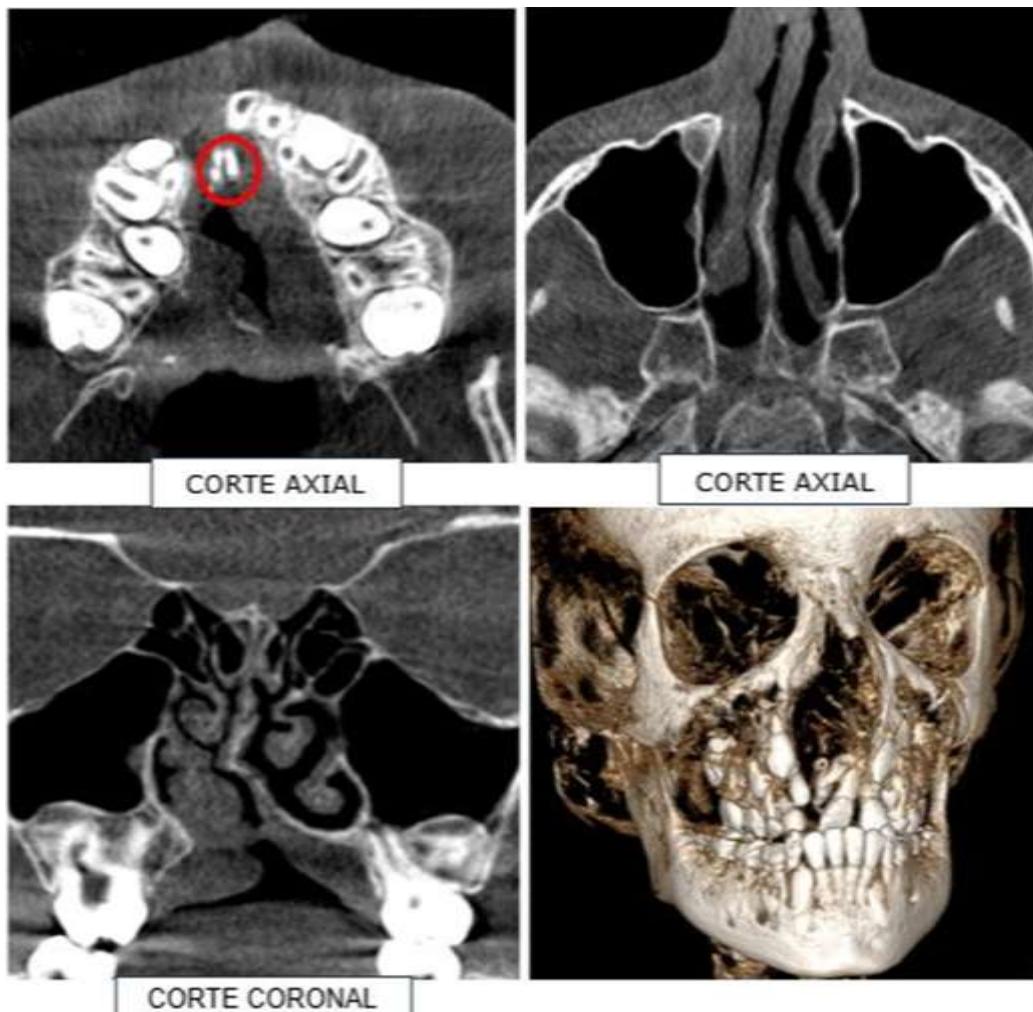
CT scan of the patient.
